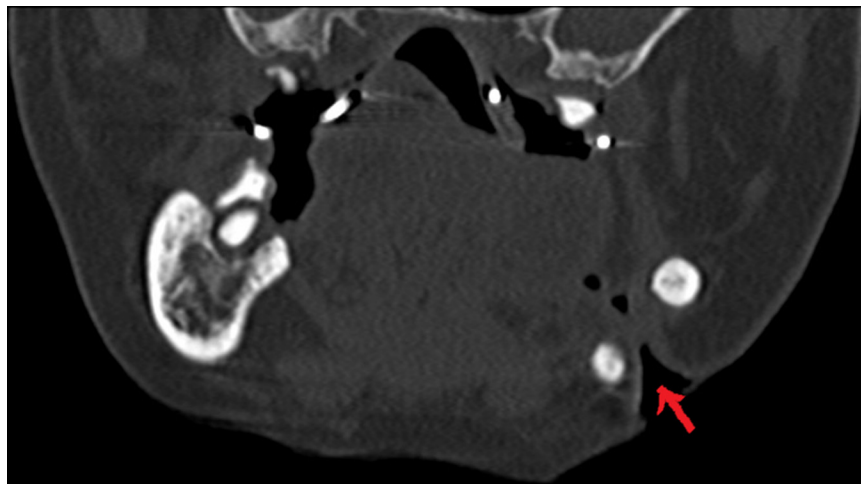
Coronal CT scan after 50 months of PENTOCLO showing bone reconstruction around the orocutaneous fistula (red arrow).
